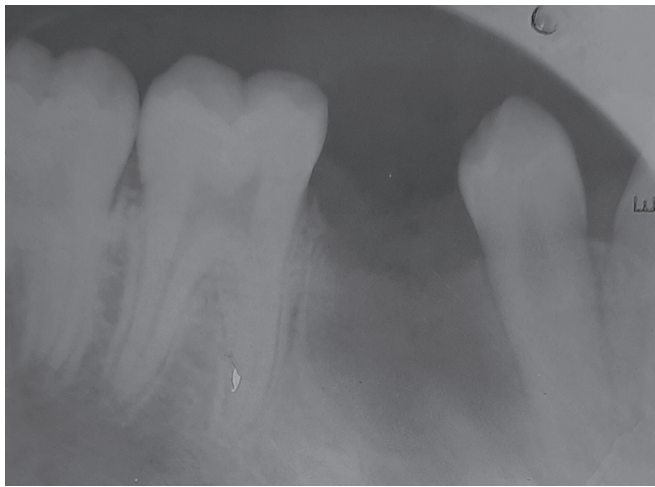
Intraoral periapical radiograph (IOPA) showing a reduction in radiolucent lesion after 3-month follow-up
